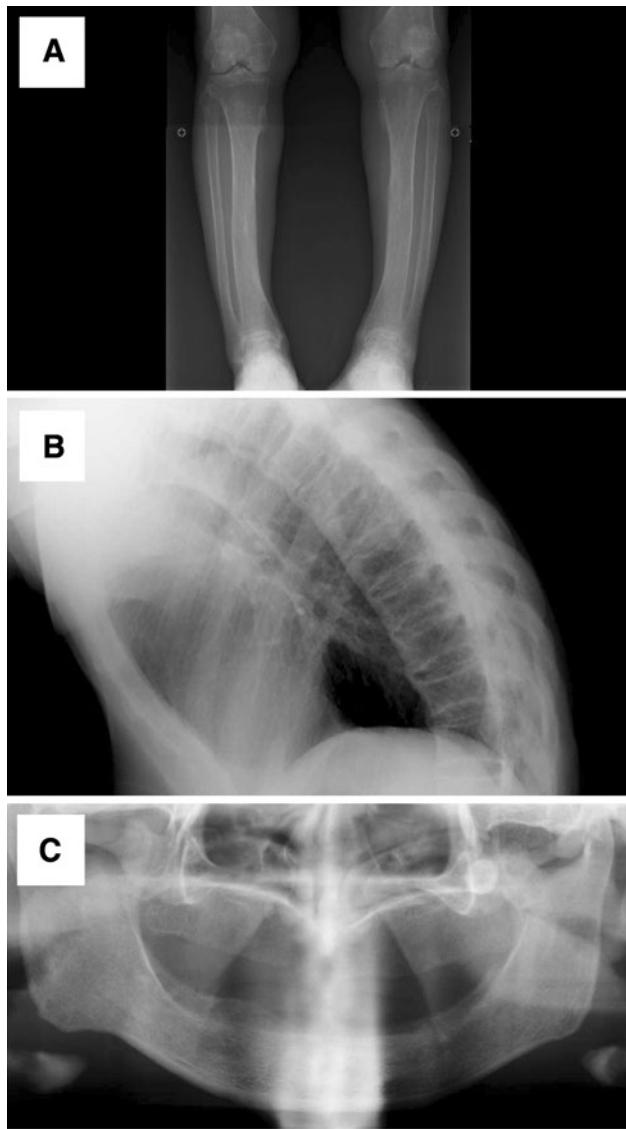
Skeletal and dental findings in patient 1 at the age of 53 years. a, b Radiographs show mild bowing of her legs and severe kyphosis. c A panoramic radiograph shows loss of all her teeth
